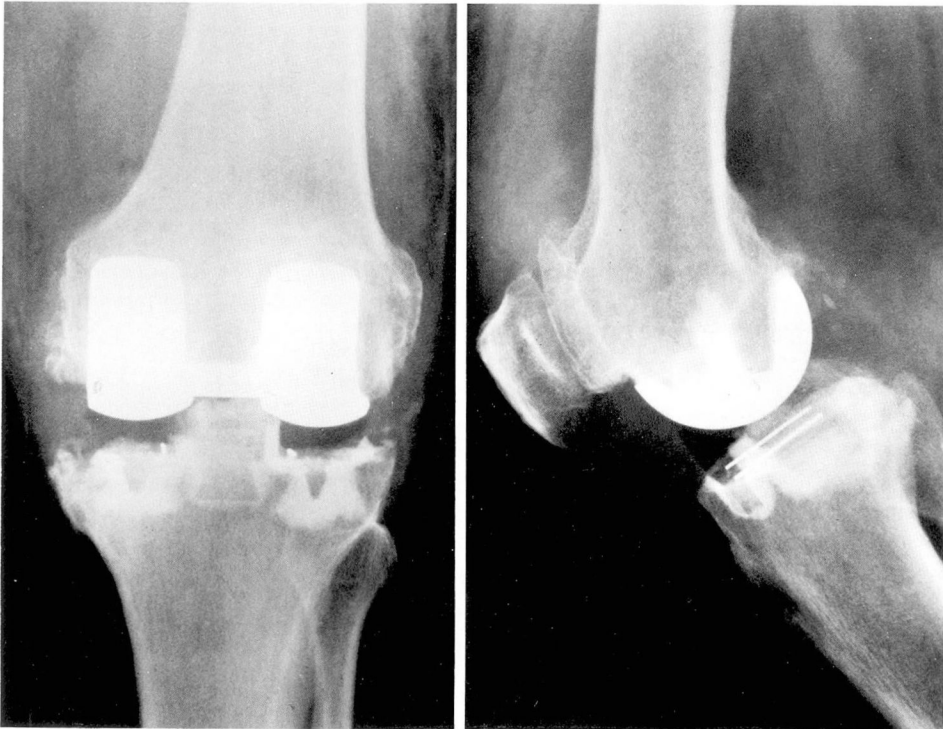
Anteroposterior and true lateral roentgenograms after geometric total knee replacement. Many of the osteophytes have been removed, and the varus deformity has been largely corrected.
